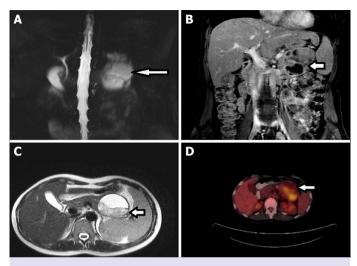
Patient 4 preoperative imaging, (A) MRCP asset imaging, (B) Coronal MRI imaging, (C) MRI T2-weighted imaging, (D) PET-CT imaging.
